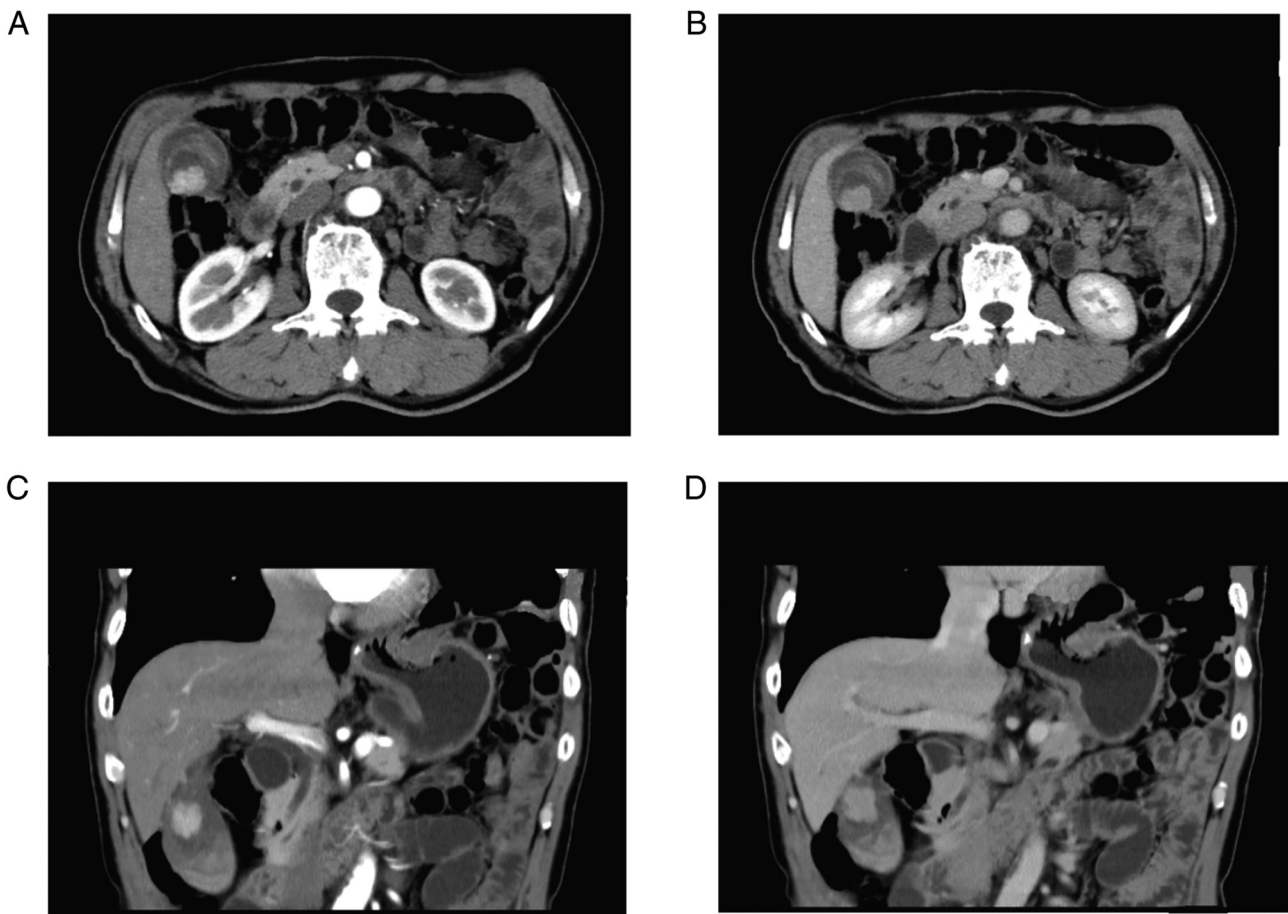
CT images of case 2. (A) Cross-sectional contrast-enhanced arterial phase CT of the abdomen. (B) Cross-sectional contrast-enhanced venous phase CT of the abdomen. (C) Contrast enhanced arterial phase CT scan of the abdomen, coronal view. (D) Contrast enhanced arterial phase CT scan of the abdomen, coronal view. CT, computed tomography.
